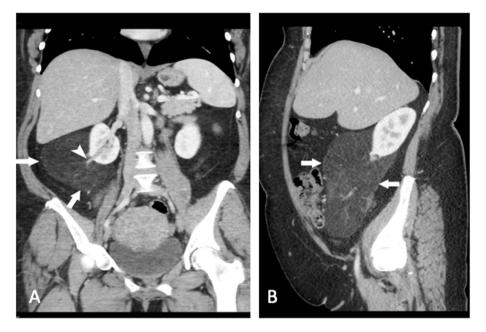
Extrarenal angiomyolipoma: Coronal (A) and sagittal (B) images of contrast enhanced CT scan shows up to 18 cm mass (arrows) with mixed fatty and non-fatty elements partially draping around the anterolateral aspect of the right kidney. No internal calcification is seen. A prominent vessel is seen arising from the renal hilum (arrowhead). The mass was surgically excised and proven angiomyolipoma at pathology.
